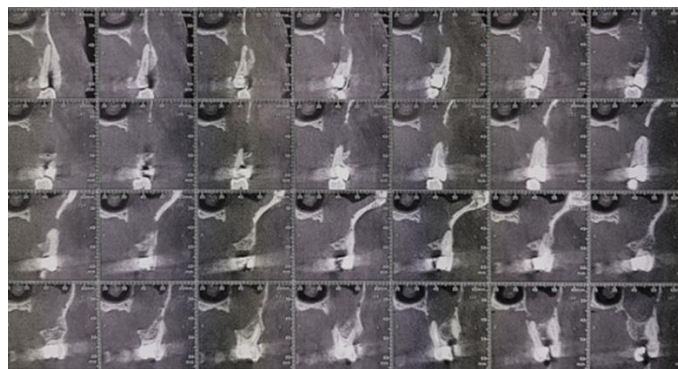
Cone Beam Computed Tomography showed bone destruction at the apical region of #24 and #25 with vestibular and palatal cortical bone disruptions.
